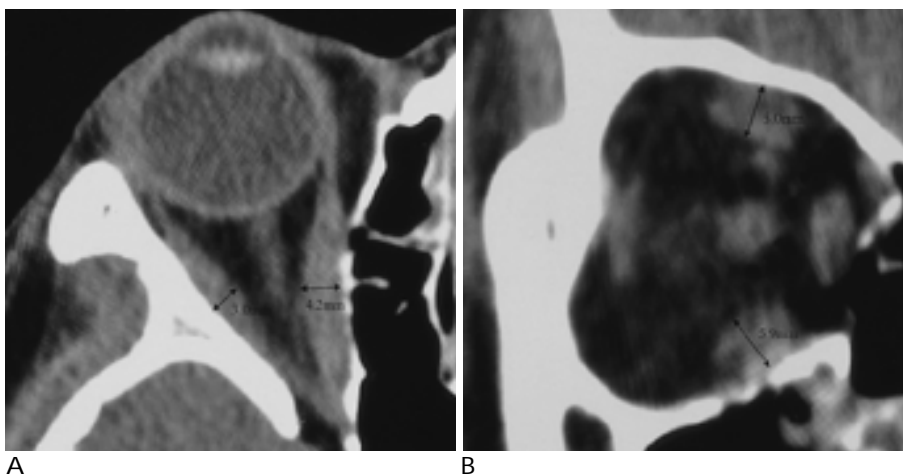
An example of the measurement of medial and lateral rectus muscles on axial (A) and superior rectus muscle complex and inferior rectus muscle on coronal (B) CT scans in a patient with thyroid ophthalmopathy.
